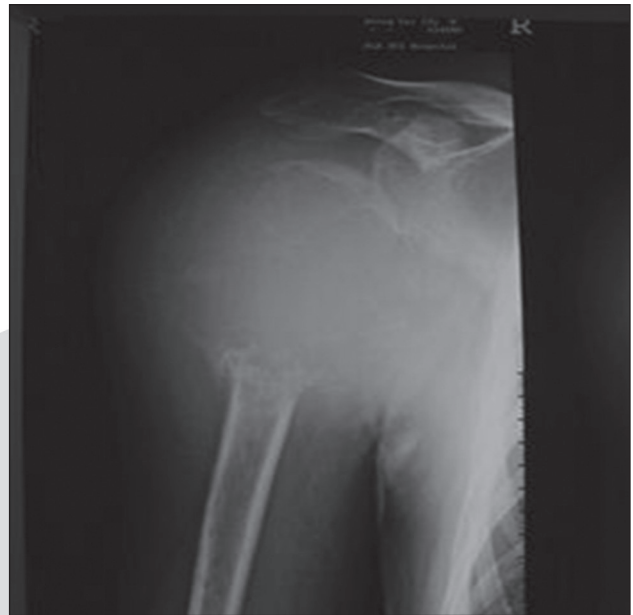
The same patient as that in Figure 3. X-ray plain film of the patient who had been followed up for 24 months. The bony shells shrank.
